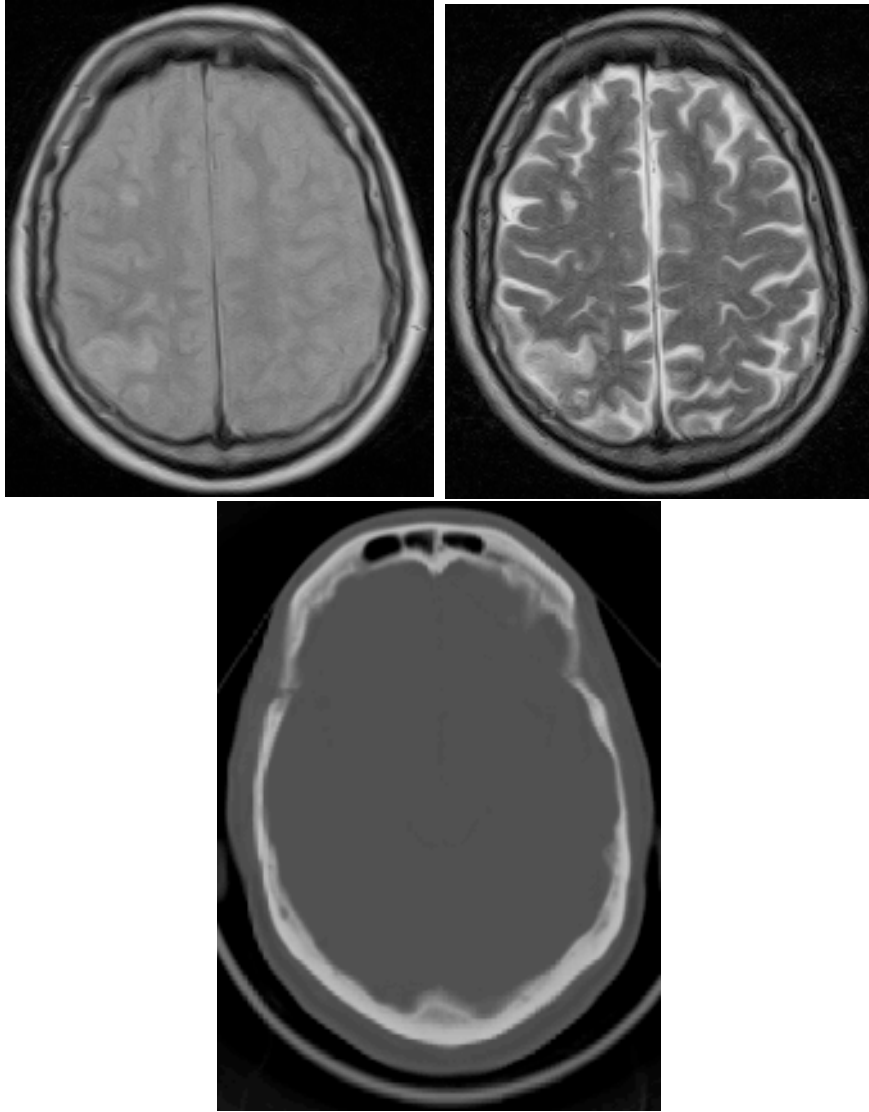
PD, T2 and CT images at uniform gray level scaling.
